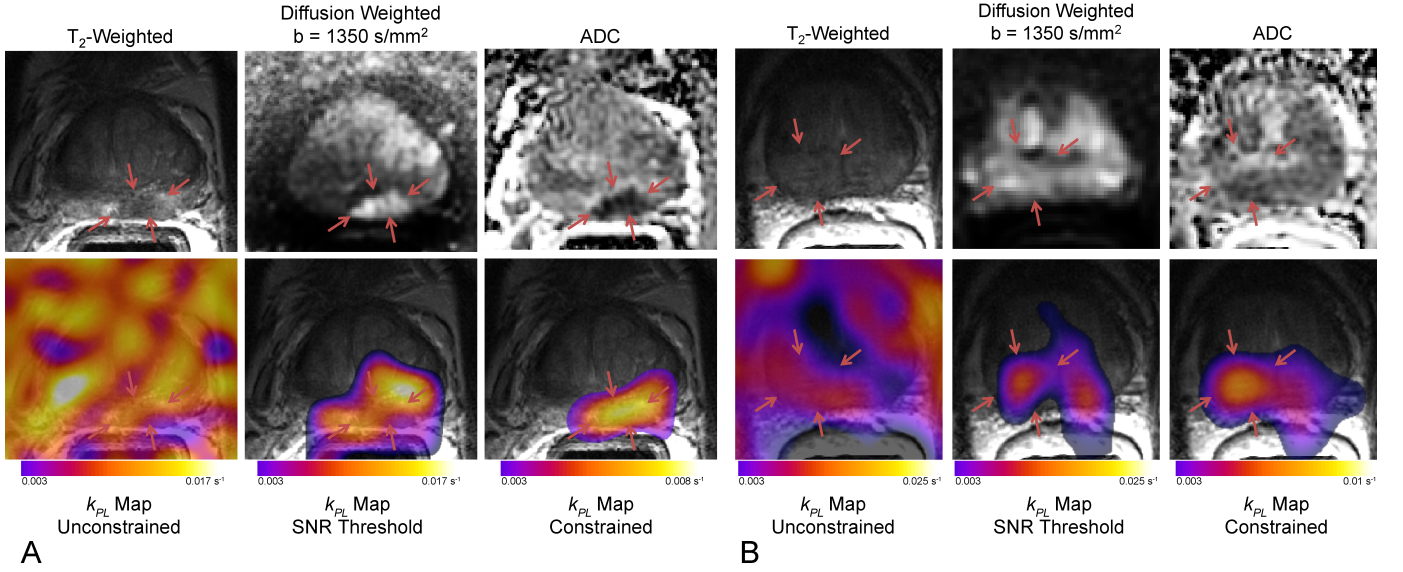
Multi-parametric  $^1\text{H}$  MRI and  $^{13}\text{C}$   $k_{PL}$  maps for the EPI (A) and EPSI (B) study showing the midgland prostate. Regions of high  $k_{PL}$  on the constrained reconstruction correlated well with biopsy proven aggressive cancer. It also agrees with lesions on multiparametric MRI, including  $T_2$ -weighted, diffusion weighted, and ADC maps (red arrows). In contrast, the lesions are obfuscated by spurious noise on the unconstrained  $k_{PL}$  maps, or require an empirical hard threshold on the pyruvate signal to visualize.
